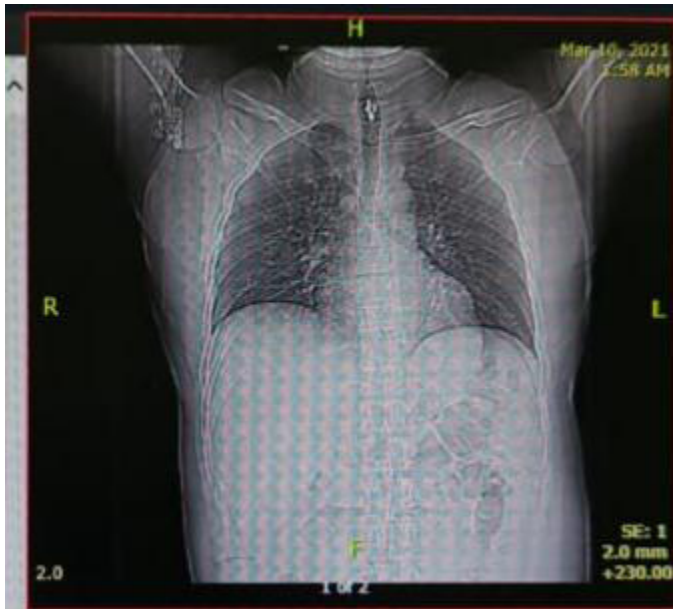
Chest X-ray of the patient on day of admission.
